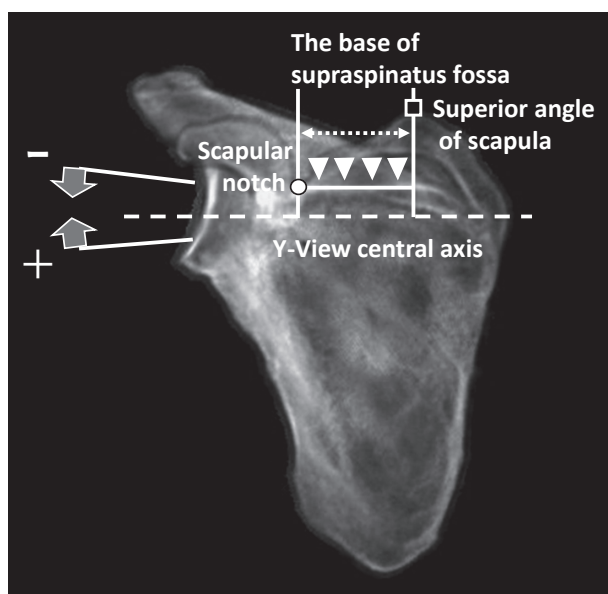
Relationship between the setting of the base of the supraspinatus fossa and the Y-View central axis in the anterior view image of the scapula in 3D-CT Raysum display
